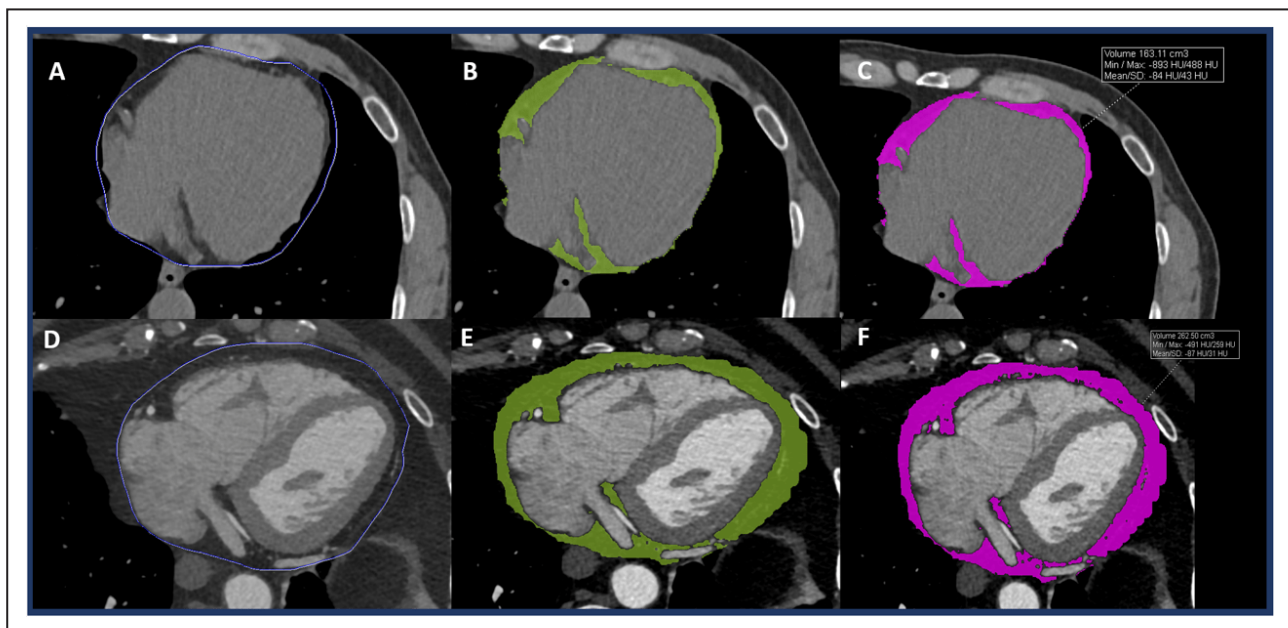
CT imaging of EFV measurement.
